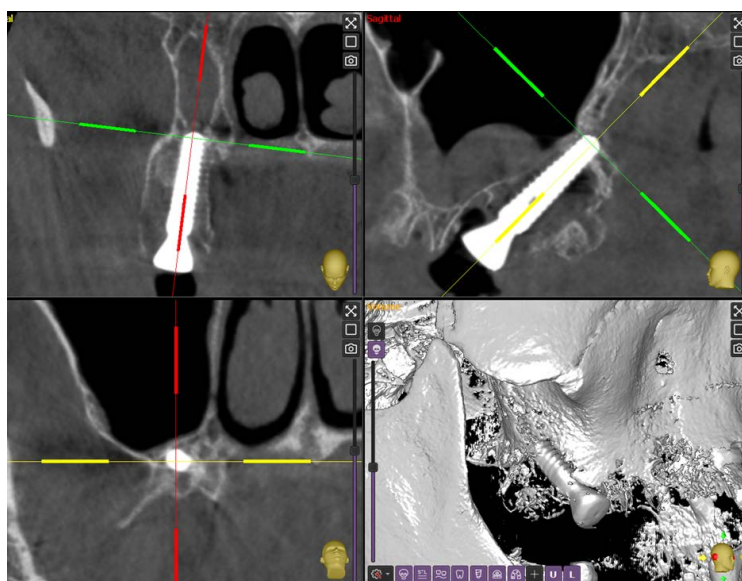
CBCT shows the technique of pterygoid implant placement in this study
